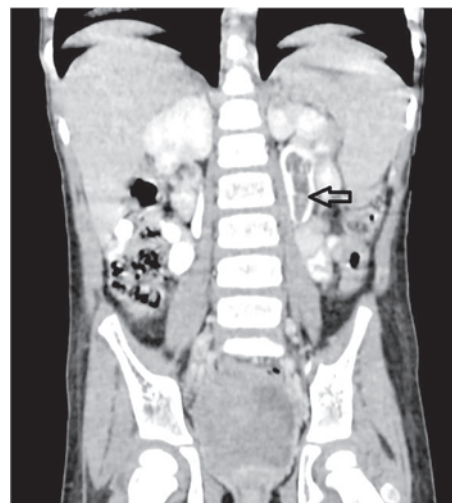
CT abdomen - Aspergillus cast in renal pelvis (arrow)
